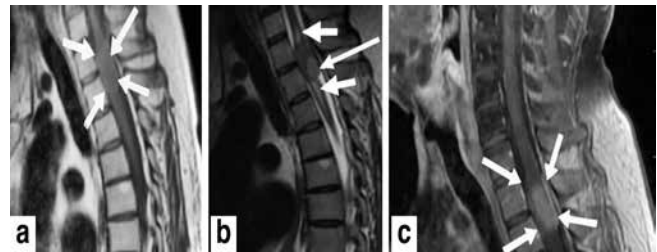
Magnetic resonance imaging revealed a lesion suspicious for metastasis on T1-2 vertebrae
